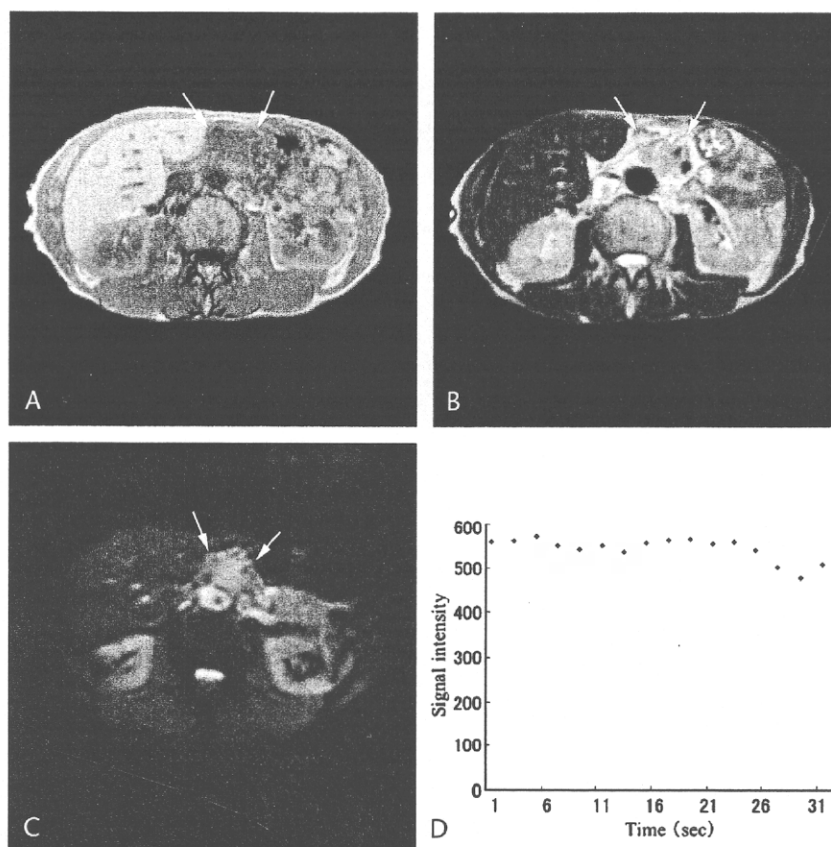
Perfusion-weighted MRI (with negative enhancement) showing low SR in a 68-year-old man with advanced pancreatic body cancer. A, T1-weighted fast gradient echo image (187/4). B, T2-weighted fast spin echo image (3150/10). C, perfusion-weighted MR pre-contrast image. D, the time intensity curve of SR. These MR images show an irregular tumor in the pancreatic body (A, B, C, arrows). The time intensity curve (D) shows a small signal drop. The SR was 12%.
